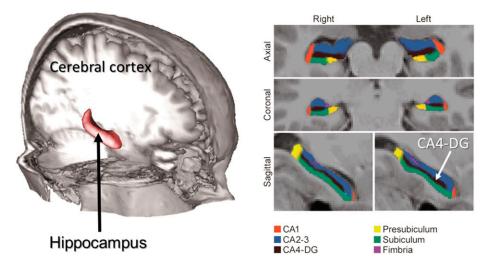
The left side of the panel shows the position of the hippocampus in the human brain. On the right, high-resolution MRI scans show the fine structure of the hippocampus in 3 orientations. The hippocampal subfields are color-coded. The subfield CA4-DG found by Köbe et al. (11) to be sensitive to vitamin B-12 status is shown in black. Reproduced from reference 12 with permission. CA4-DG, CA4-dentate gyrus.
